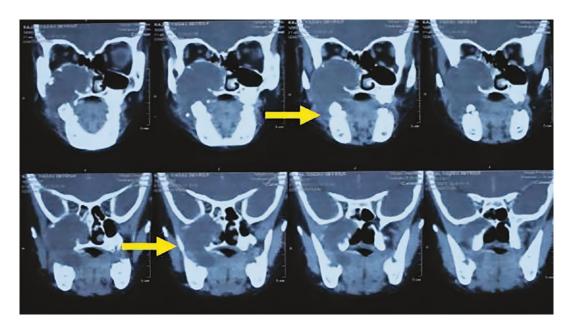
CT scan: coronal cuts showing the lesion in the right maxilla with the erosion of the anterolateral wall of the maxilla
